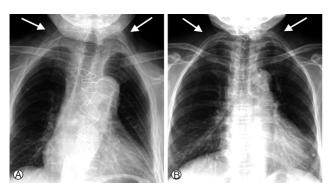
Elevated upper rib cage (white arrows) on the chest radiograph in case 1 (A) and case 2 (B).
